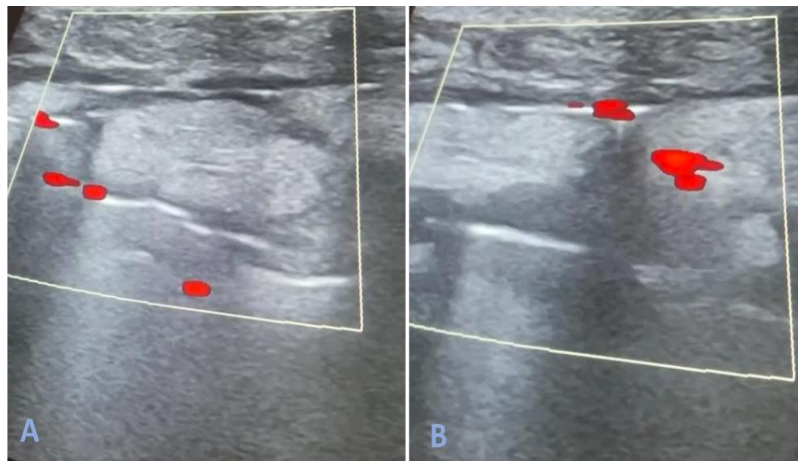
Power Doppler – mild panniculitis and fat presence from the omentum tissue positioned during surgery at the level of the jugular vein, with normal Power Doppler flow at the same level.
